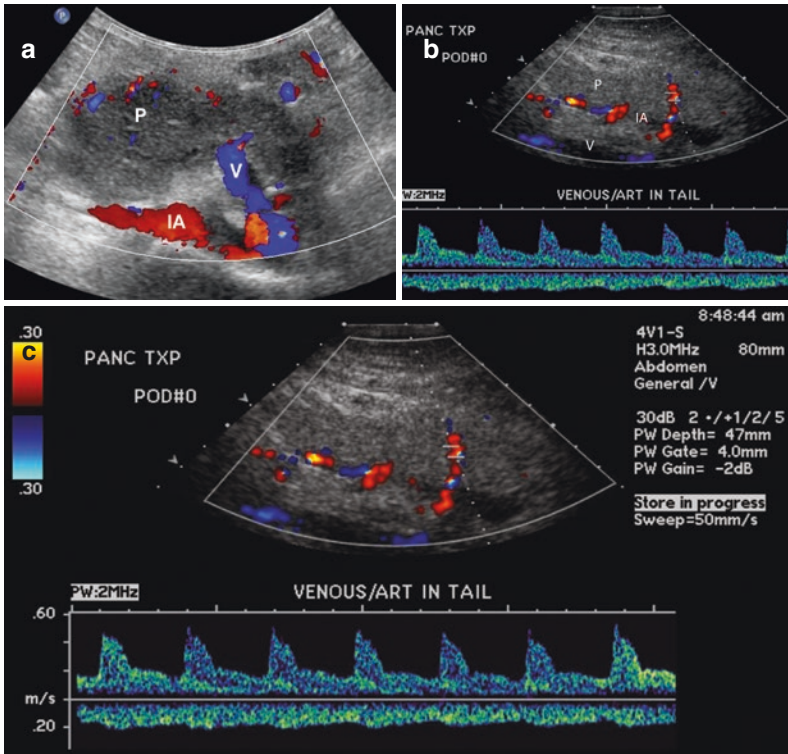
(a) Doppler image of the pancreas transplant (P), iliac artery (IA), and transplant vein (V). (b) Doppler interrogation of the pancreatic tail demonstrating mixed arterial and venous flow. Patency of the transplant vessels is usually evaluated by ultrasound in the immediate postoperative period
